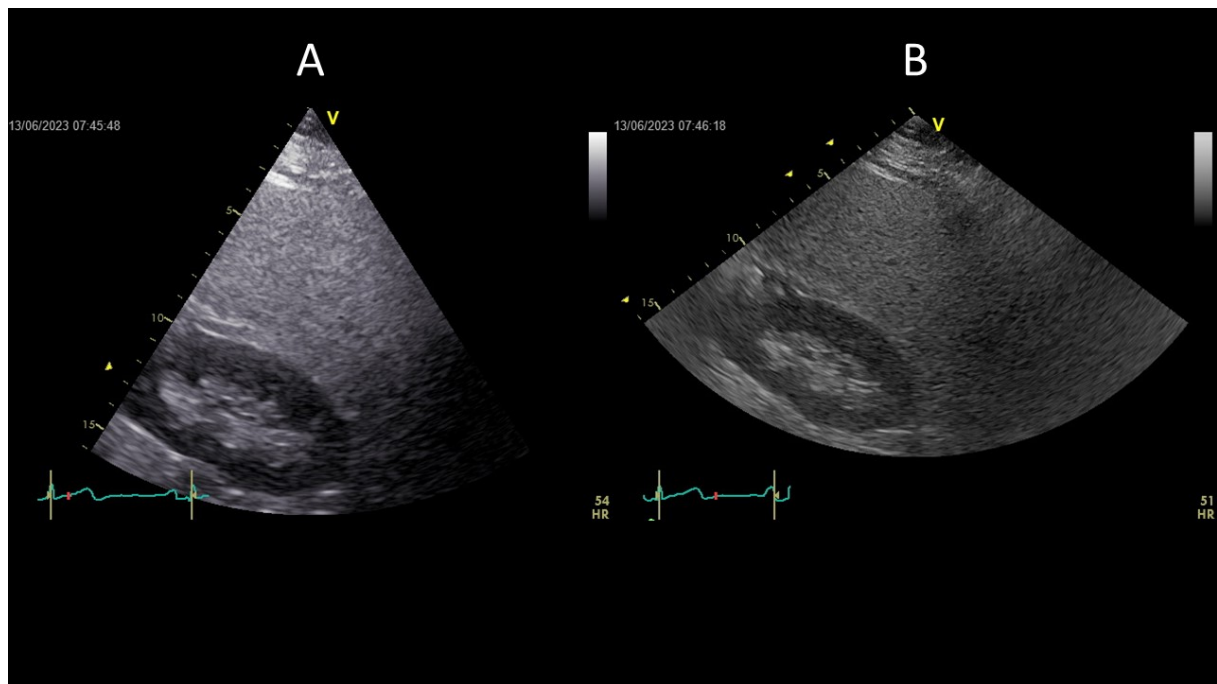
Cardiologic (A) and abdominal (B) ultrasonographic preset
